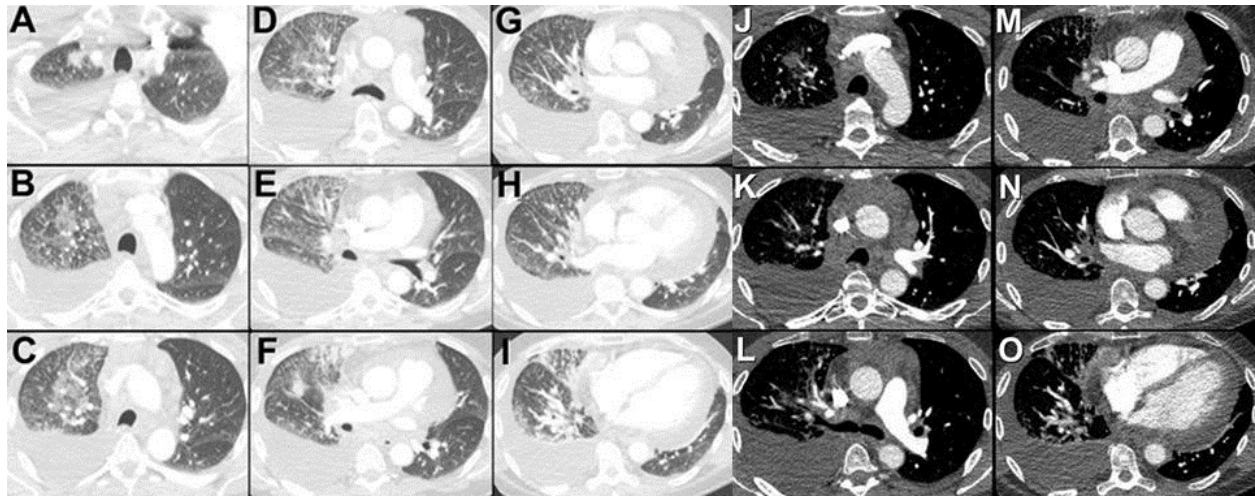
Representative static enhanced thoracic CT displayed in lung (A-I) and soft tissue (J-O) windows.
